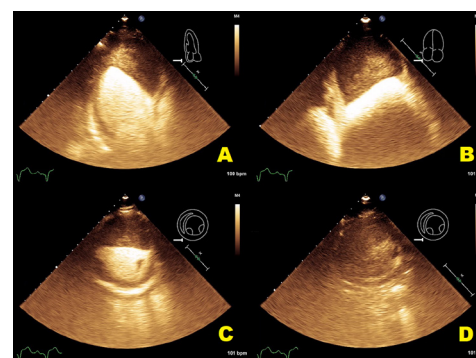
Transthoracic echocardiography with contrast highlighting the size and location of the biventricular thrombi. The contrast somewhat penetrates the left ventricular thrombus, indicating that it is not solid and is evolving. (A) Three-chamber view demonstrating the size and shape of the left ventricular thrombus; (B) standard four-chamber view demonstrating the defined border between the thrombus and the contrast-filled cavity and (C) short-axis view at the level of the mitral valve highlighting the partial opacification of the chamber at this level. The right ventricle is wholly opacified at this level and (D) short-axis view more apically displaced than (C), demonstrating total opacification of both chambers by thrombus. bpm, beats per minute.
